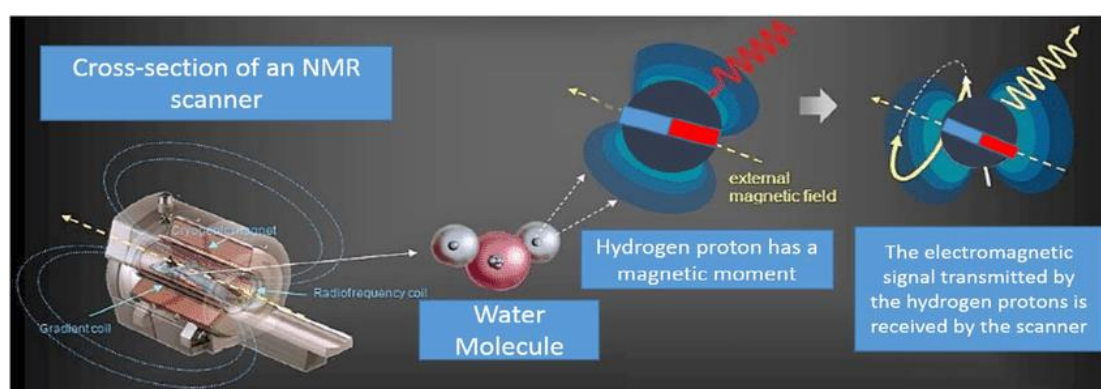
The principle of MRI (Deene, 2017).
